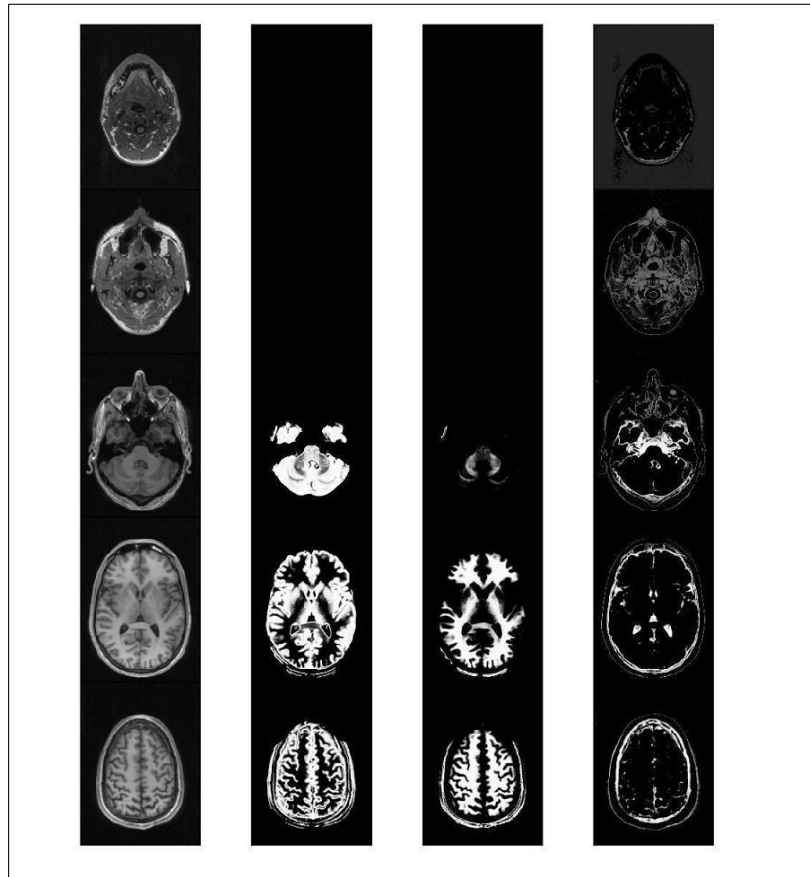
Axial slices of the segmented raw MRI data and the gray matter, white matter and CSF images
